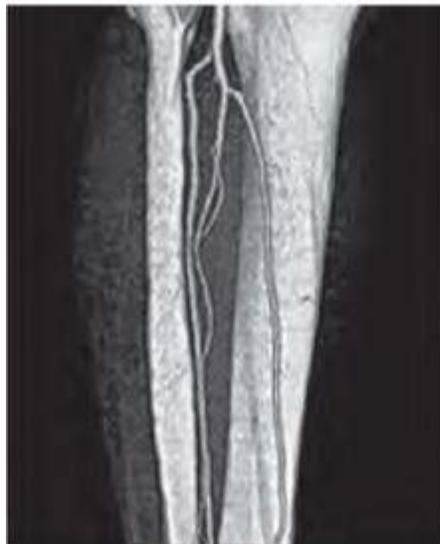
A. A multidetector computed tomographic angiography of a patient with an infrapopliteal arterial circulation
